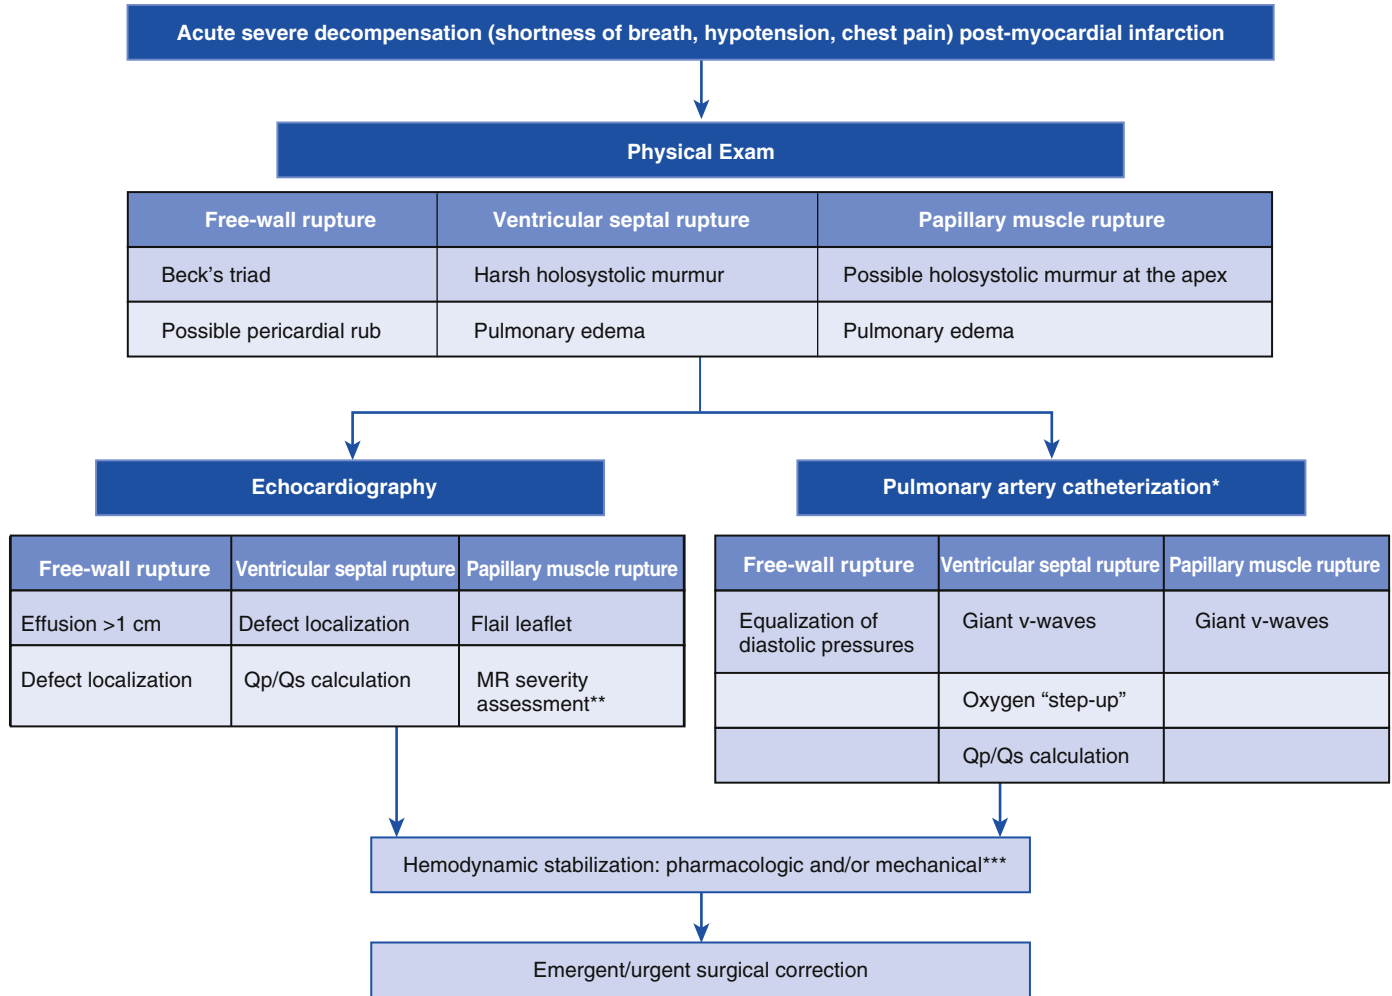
Assessment of acute severe decompensation after myocardial infarction. *Pulmonary artery catheterization is not required to confirm diagnosis. If already in place, findings can be supportive and/or suggestive. To be performed if echocardiographic findings are unclear. Using standard color, continuous-wave and pulse-wave Doppler evaluation, pulmonary venous flow assessment, regurgitant volume, and fraction calculation. *Pharmacologic therapy (vasodilators, inotropes, or vasopressors) and mechanical support uses are dependent on systemic blood pressure and should not delay surgical intervention. *MR*, Mitral regurgitation.
